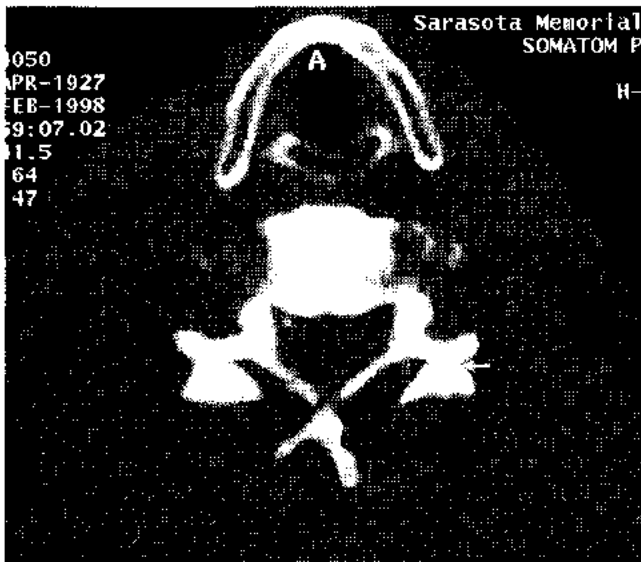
Computed tomography scan of C5. The facets are bilaterally dislocated.
